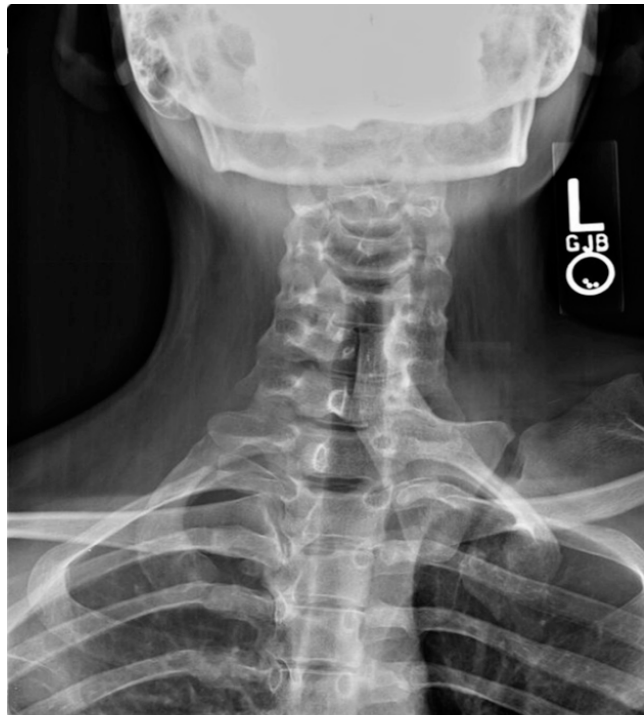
X-Ray imaging demonstrating the omovertebral bone between the posterolateral spinal elements of the C5, C6, and C7 vertebrae and the superomedial border of the scapula. Also note the congenital fusions between the C5, C6, and C7 vertebrae [43].
